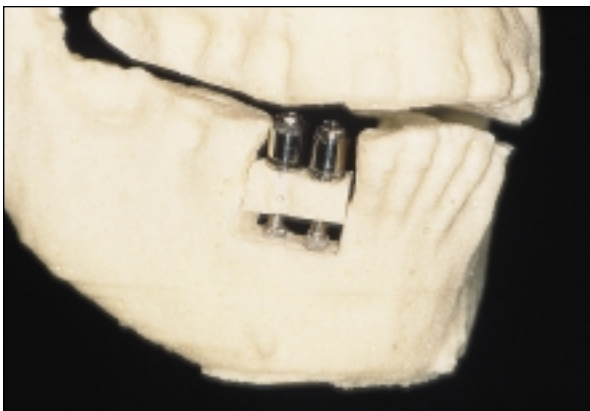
Operative planning with the aid of a computed tomography-based milling model in a patient with an alveolar ridge defect.
